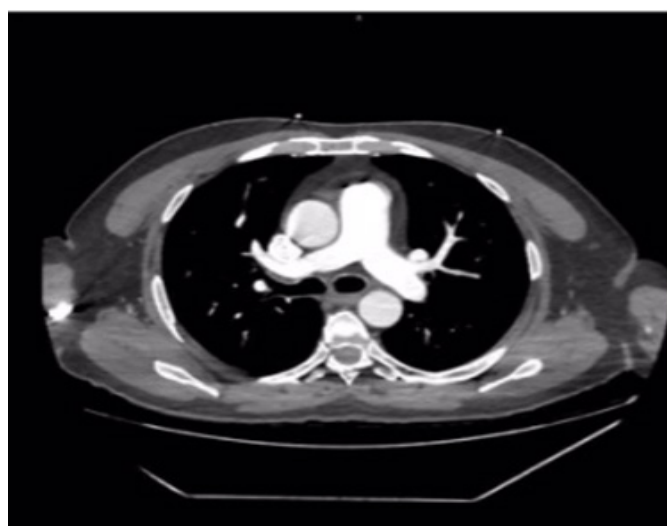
Aortic dissection is not present in the computed tomography angiography
